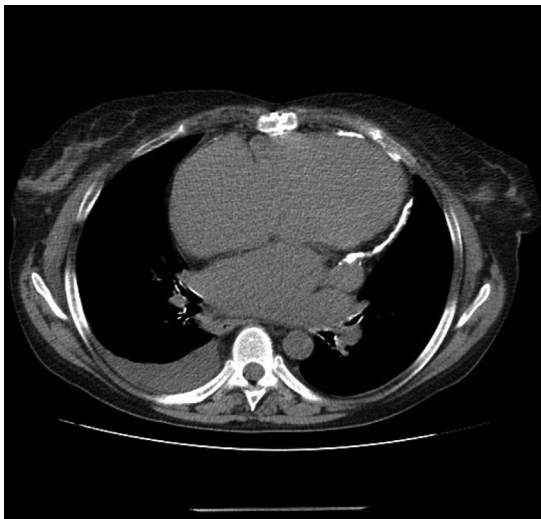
Cardiac computed tomography: pericardial calcification.
